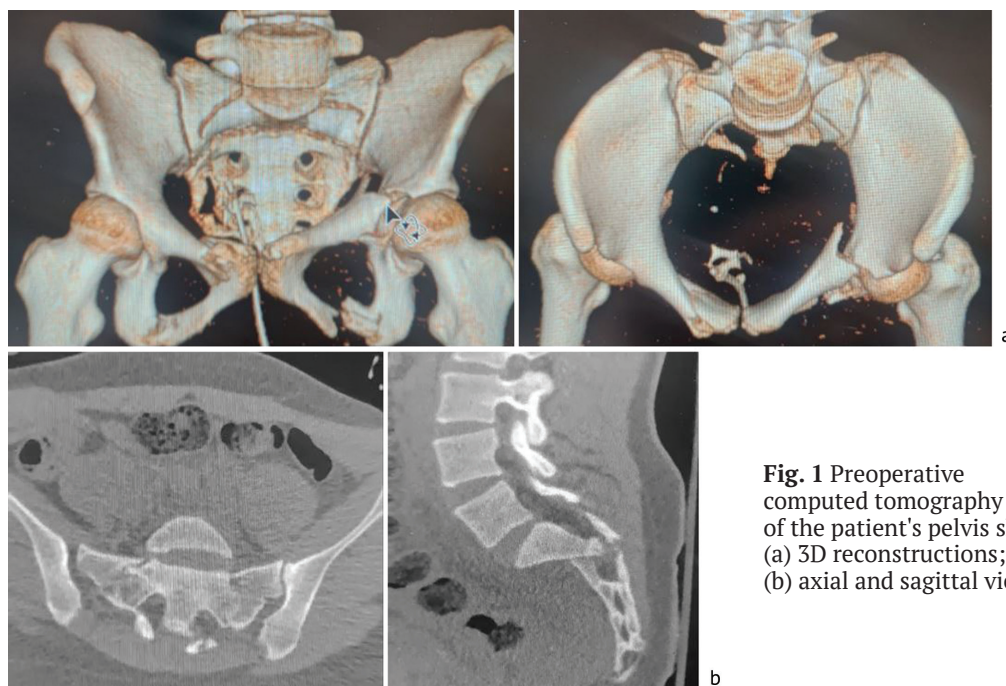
Preoperative computed tomography scans of the patient's pelvis showing (a) 3D reconstructions; (b) axial and sagittal views
